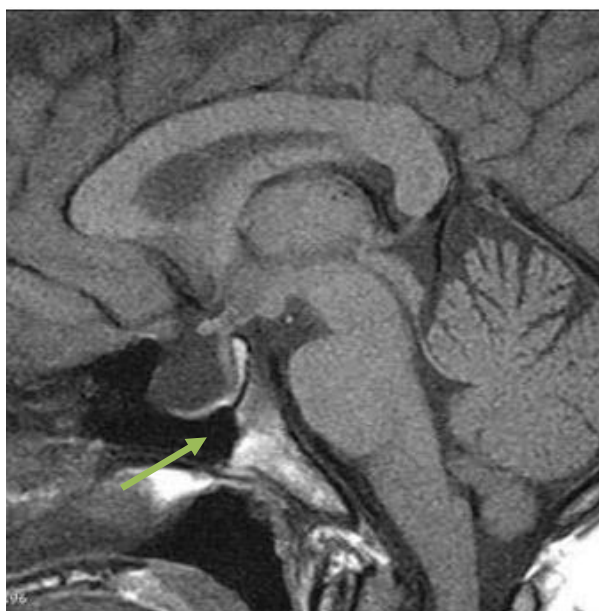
MRI showing empty sella (pointed by arrow)
